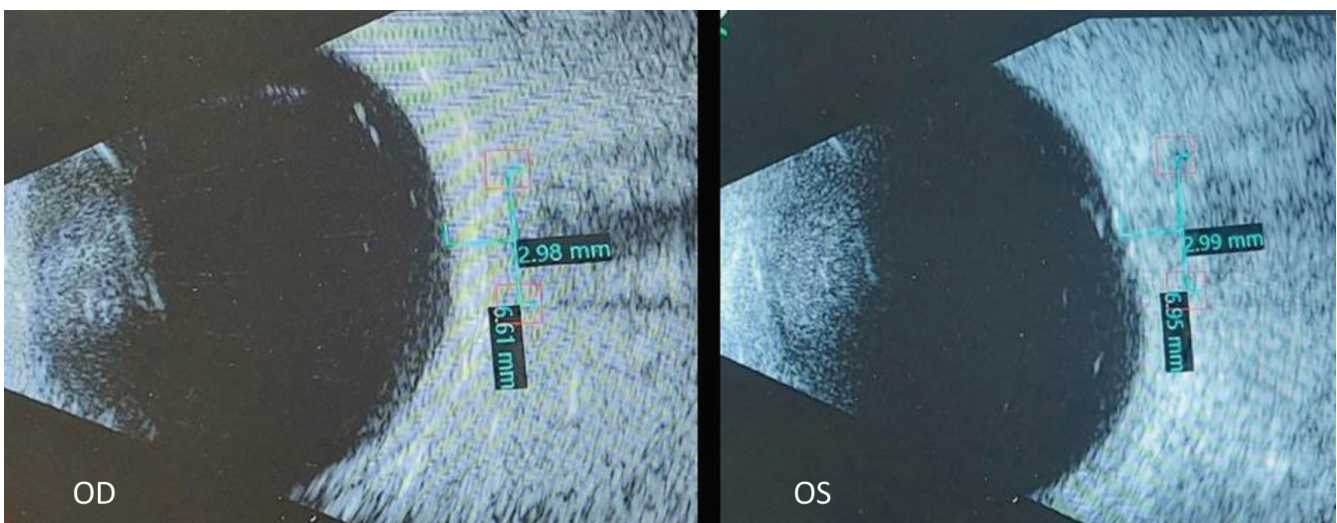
Ultrasound measurement of optic nerve sheath diameter at 3 mm behind the globe shows thickening and dilatation
